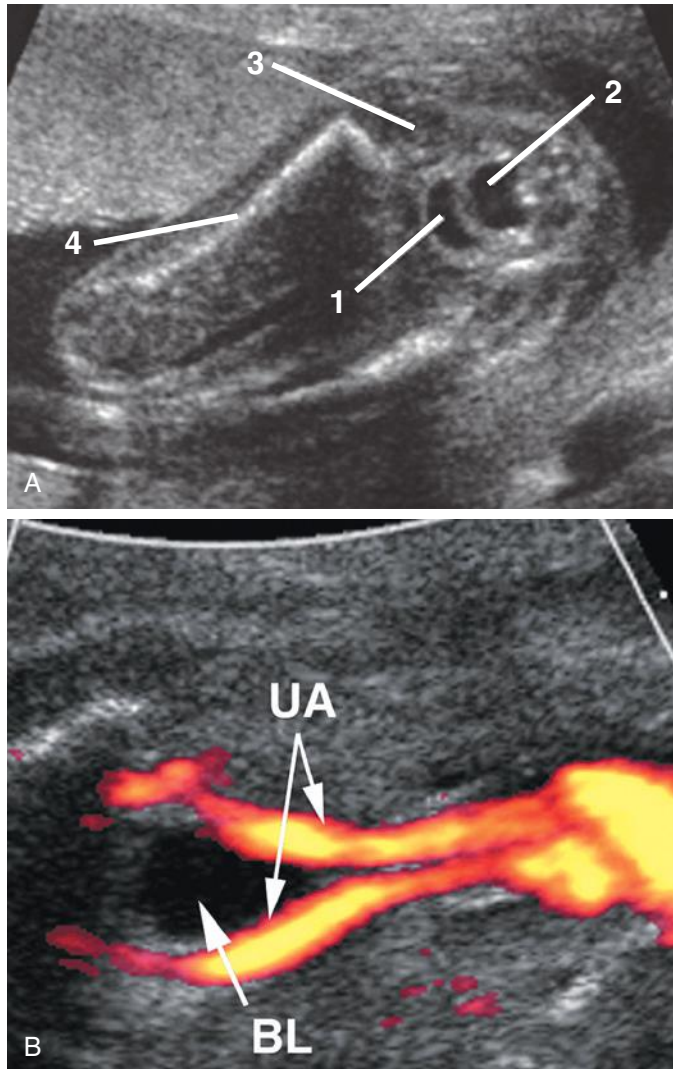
A, Transverse axial sonogram through the fetal pelvis. 1, urinary bladder; 2, rectum; 3, femoral head; 4, femoral diaphysis. B, Oblique axial sonogram through the fetal pelvis with nondirectional color Doppler. The umbilical arteries (UA) mark the lateral margins of the bladder (BL).
